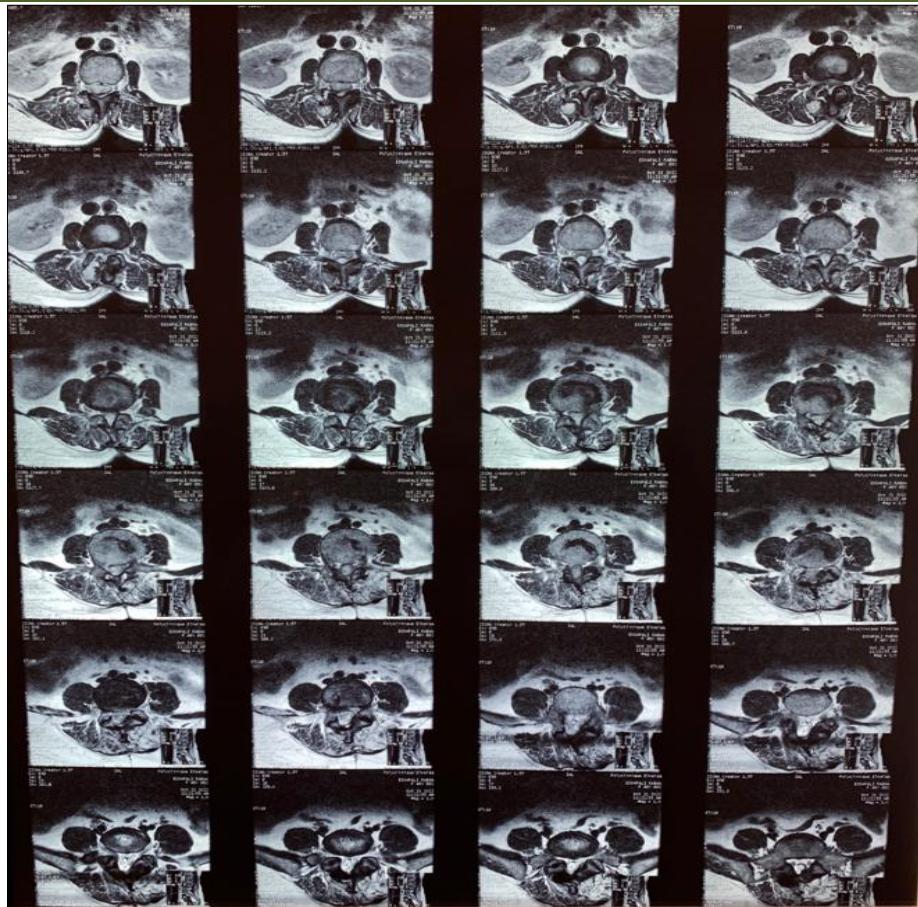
CT Lumbar Spine
